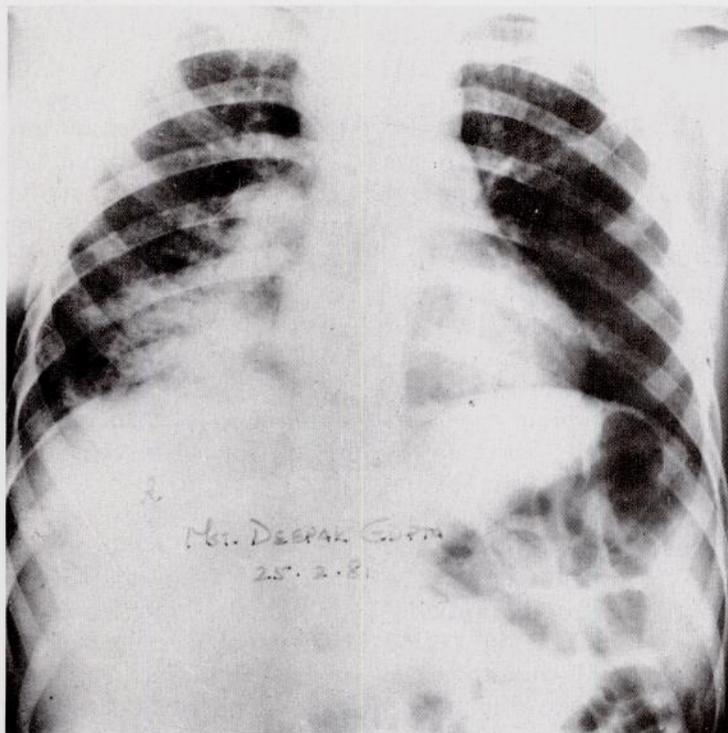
Chest radiograph (February 1981) shows evidence of pneumonia.
